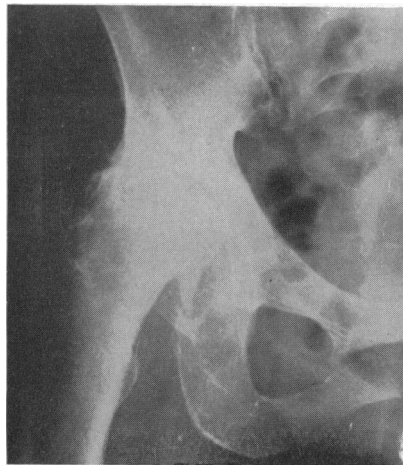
Radiograph of right hip after six months' treatment. Note marked osteoarthritic change with loss of joint space, sclerosis, and flattening of femoral head.
